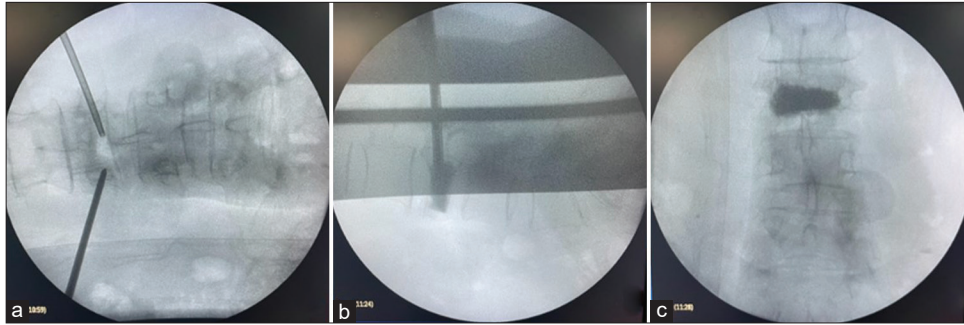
Intraoperative fluoroscopy images, showing (a) AP X-ray with the presence of transpedicular cannulas, Subsequently, (b) lateral X-ray is observed during cement injection through the cannula in the vertebral body, Finally, (c) AP X-ray with the presence of intracorporeal cement at the end of the procedure and removal of cannulas.
